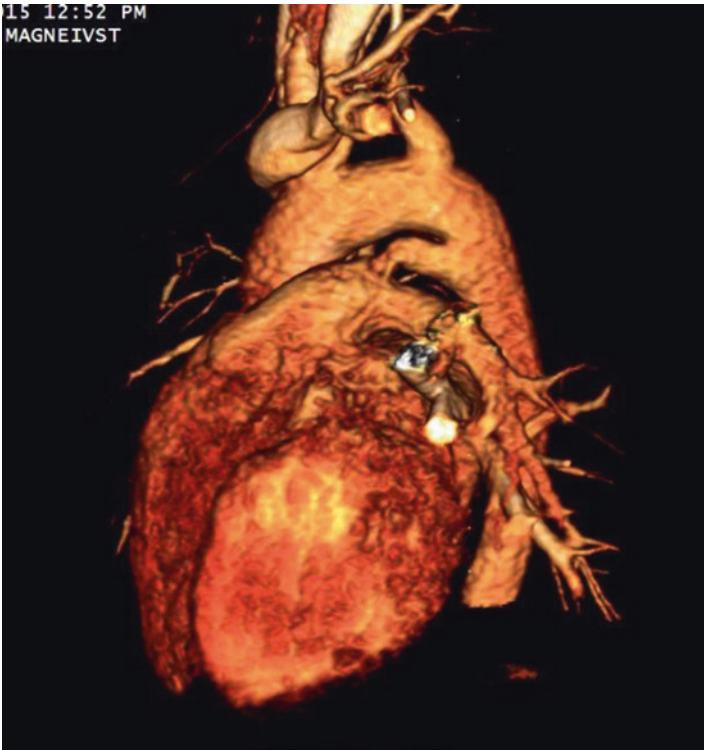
3-dimensional rendered image of a patent ductus arteriosus by CT angiography. The aortic connection is distal to the left subclavian artery
